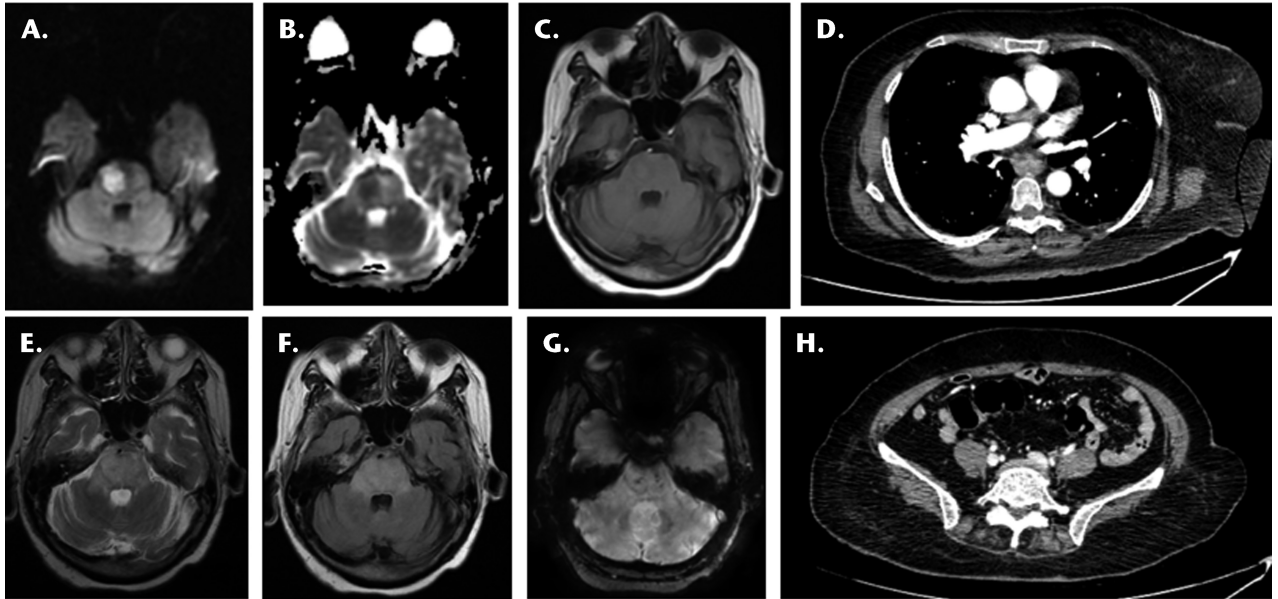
Magnetic resonance imaging of the brain showed persistent diffusion restriction in pons (A) with corresponding hypointensity on apparent diffusion coefficient (B). There was a significant reduction in brainstem swelling with persistent signal alteration on T2/FLAIR sequences (E and F). A note of the punctate areas of blooming in gradient imaging was made, suggestive of hemorrhage (G). Contrast-enhanced CT of the chest and abdomen showed resolution of thrombus in the left pulmonary artery (D and H).
